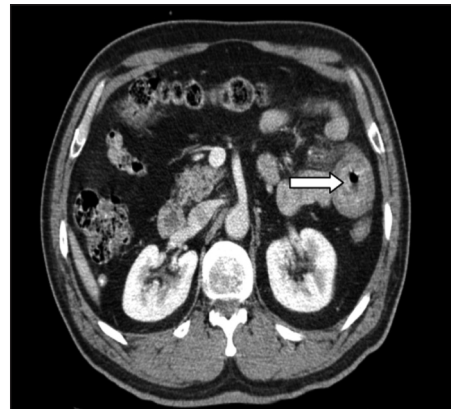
Abdominal computed tomography showing intramural hematoma.
